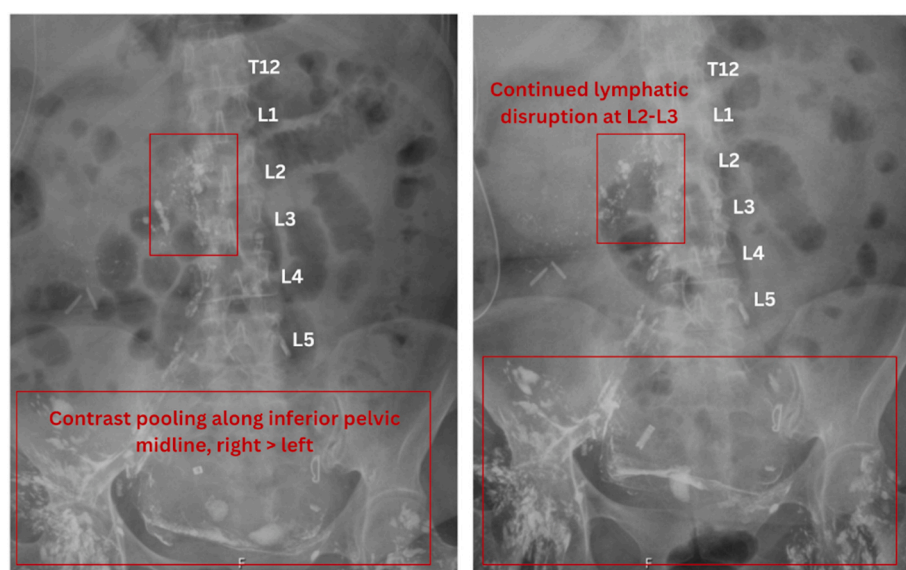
Serial abdominal x-rays POD38-39 visualizing accumulation of contrast along the inferior pelvic midline consistent with a chylous leak.
